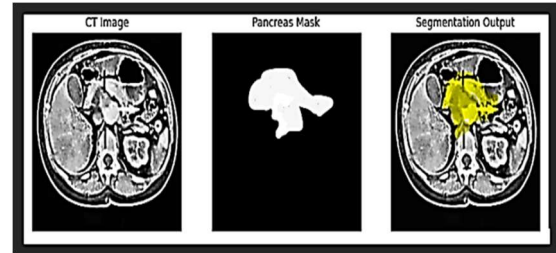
TransUNet-based segmented CT image along with the Pancreas Mask
